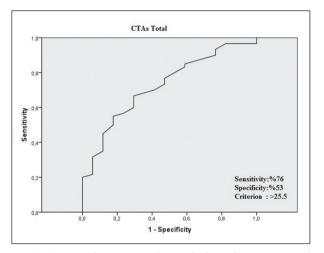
CTAs evaluation according to high resolution computed tomography involvement
